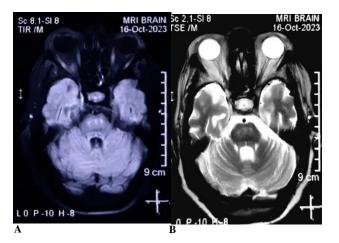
(A and B): CE-MRI T2W and FLAIR sections showing pontine hyperintensities.
